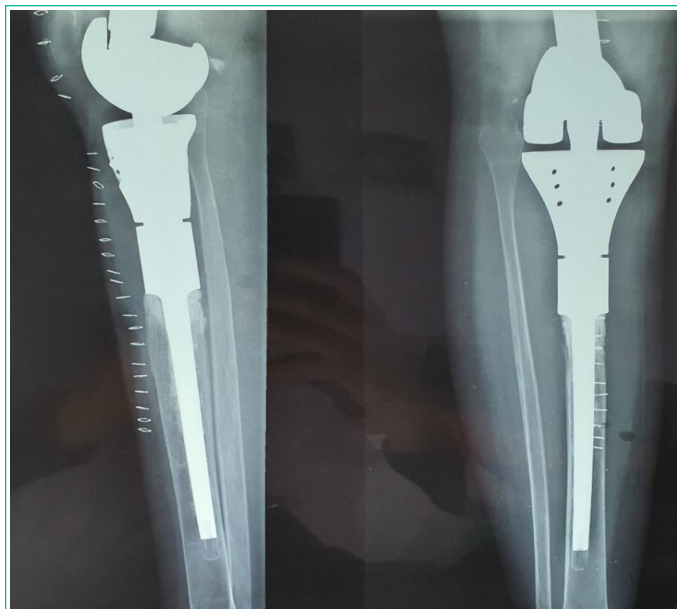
Standard front and profile X-ray of the massive right knee prosthesis.
